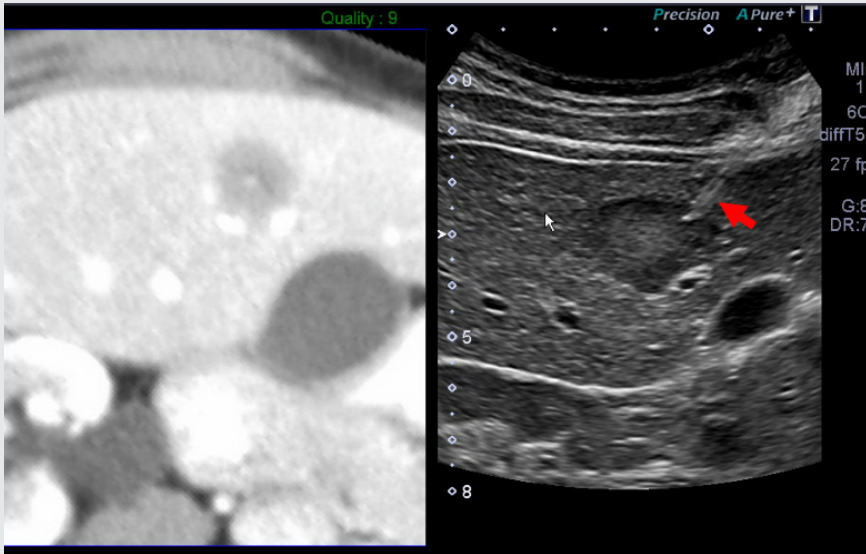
The biopsy needle (red arrow) is clearly visualized entering the liver mass in the live ultrasound image using a right subcostal approach.
